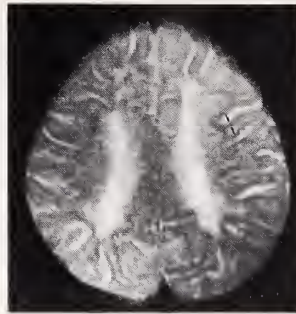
T2-weighted image revealing low signal intensity in cerebral cortex.
